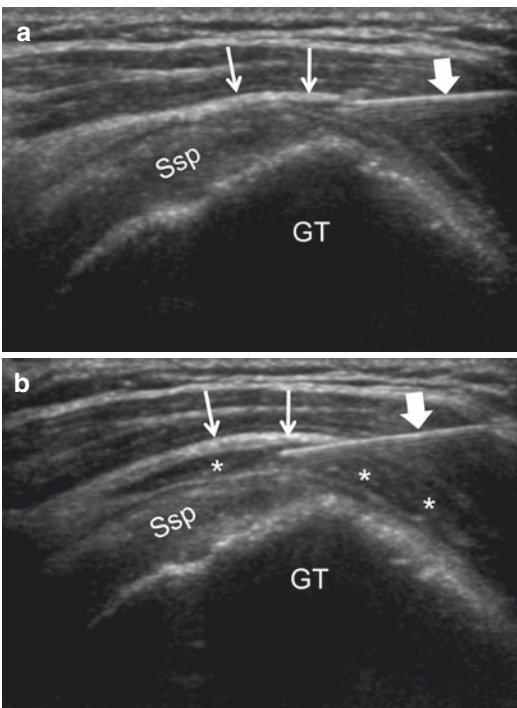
Ultrasound images (a and b) demonstrate needle placement, for SASD bursal injection, with the tip of the needle (block arrow) within the echogenic peribursal fat (thin arrows). Postinjection, there is smooth distention of the SASD bursa with injectate (*, b). Note that the bursa extends lateral to the rotator cuff insertion. *Ssp* supraspinatus, *GT* greater tuberosity
